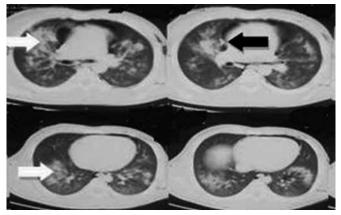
Contrast enhanced computed tomography of the chest showing of bilateral consolidation of lung fields (white arrows) with pneumomediastinum (black arrow).
